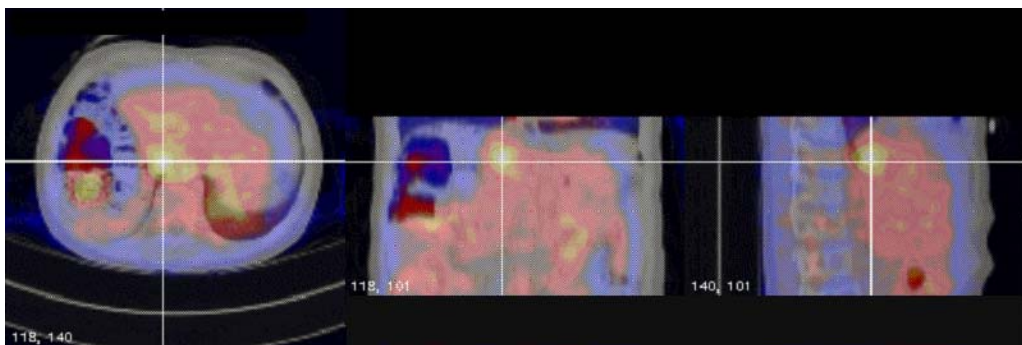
The area of recurrence of hepatoblastoma was unremarkable in CT. A study of fluorine 18-fluorodeoxyglucose (¹⁸F FDG) was performed showing focal localisation of the disease. Fusion of FDG and CT is shown in three orthogonal sections (left to right: transverse, coronal and sagittal). Increased uptake of ¹⁸F FDG in the receptor area indicated the corresponding location in the CT.
